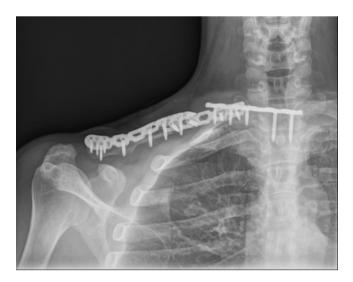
X-ray taken at 23 months after surgery, showing that the fractured area at 11 months after surgery was well fused. An angular deformity and sternal screw loosening with medial plate pull-out were observed. Since there were no indications of additional pain or discomfort, further observation was performed.
